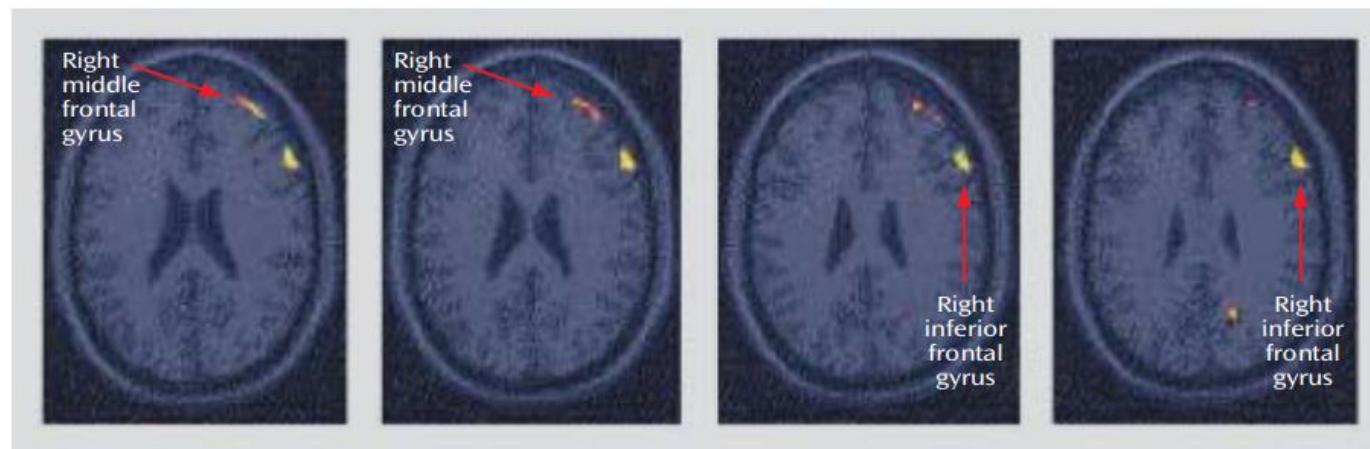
Statistical Parametric Map Overlaid on an MRI Template Showing Brain Areas of Greater Increases in Blood Flow During a Verbal Memory Encoding Task in Healthy Subjects (N=9) Than in Subjects With Depression (N=18)<sup>a</sup>
